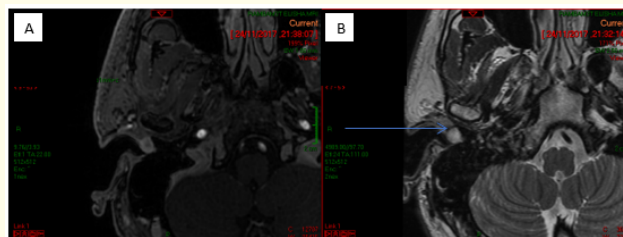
MRI (A) T1 with gadolinium and (B) T2 sequence, demonstrate a clear separation between the parotid gland and the finding and homogenic enhancement of the lesion with gadolinium (arrow).
